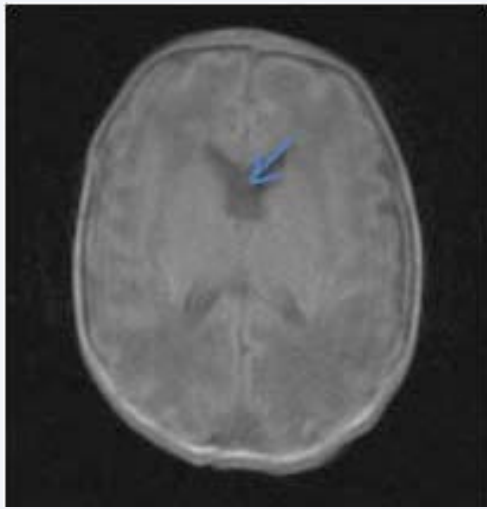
Case 4-MRI brain showing absent septum pellucidum.
